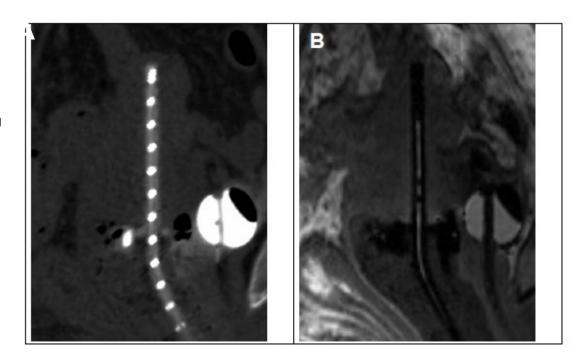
Sagittal MRI images on A) CT (Philips Brilliance large bore CT) and B) 3D T1W MPRAGE MRI (3.0T Siemens Skyra MRI) of a plastic ring and tandem applicator *in vivo*. To visualize the lumen of the ring and tandem applicators, an x-ray marker wire and an in-house fabricated marker filled with gadolinium-doped water was inserted in the applicators during CT and MRI acquisition, respectively. The absence of a hyperintense signal at the tip of the tandem on MRI versus CT, is an indication of the presence of air-bubbles in the MRI marker. (Please note, given the contrast agent used for the in-house marker, it was not visible on T2W images. If a marker with a T2W contrast is used, a similar void may be expected in the presence of an air-bubble.)
